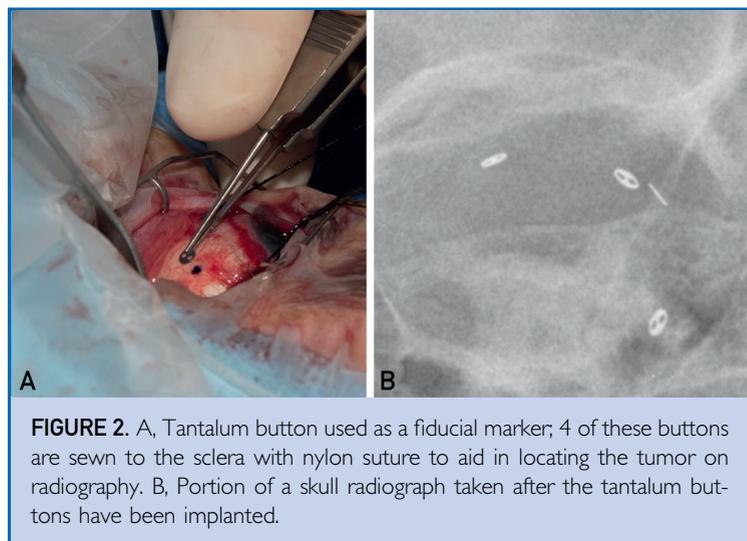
A, Tantalum button used as a fiducial marker; 4 of these buttons are sewn to the sclera with nylon suture to aid in locating the tumor on radiography. B, Portion of a skull radiograph taken after the tantalum buttons have been implanted.
